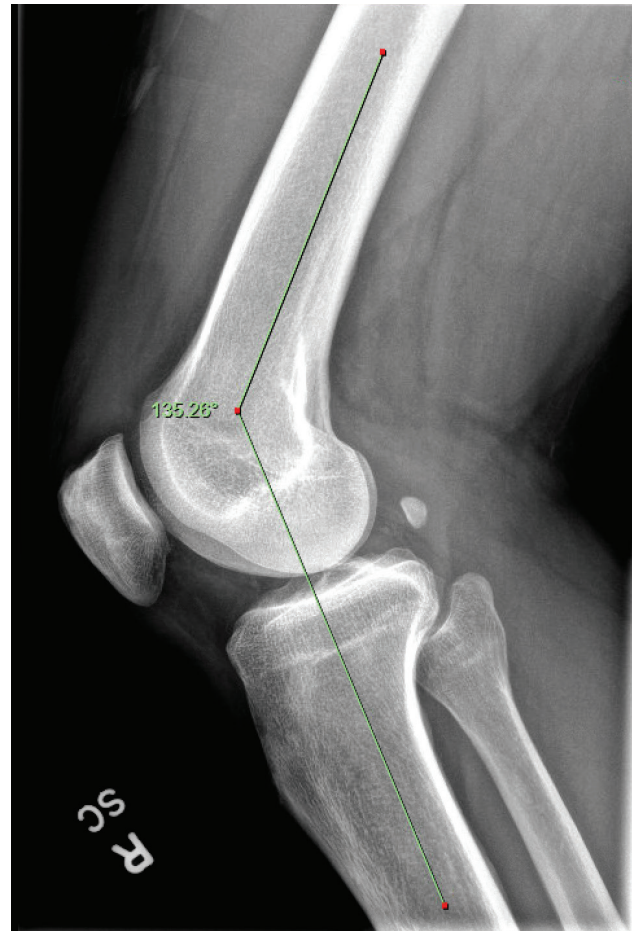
Measuring the angle of knee flexion. Example of the radiology application measurement on a lateral knee X-ray. The green line indicates the angle of knee flexion with the value calculated through the application.
